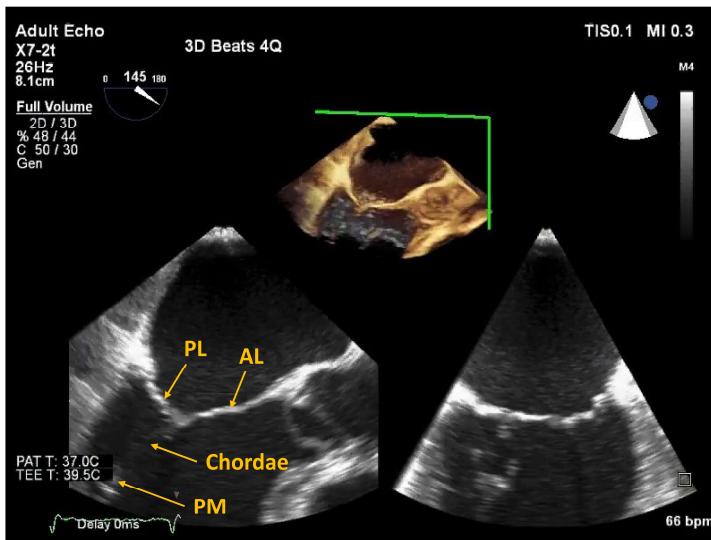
Echocardiographic image of healthy mitral valve at peak systole. The main components of the valve structure can be seen: anterior (AL) and posterior (PL) leaflets, posteromedial papillary muscle (PM) and chordae tendineae
